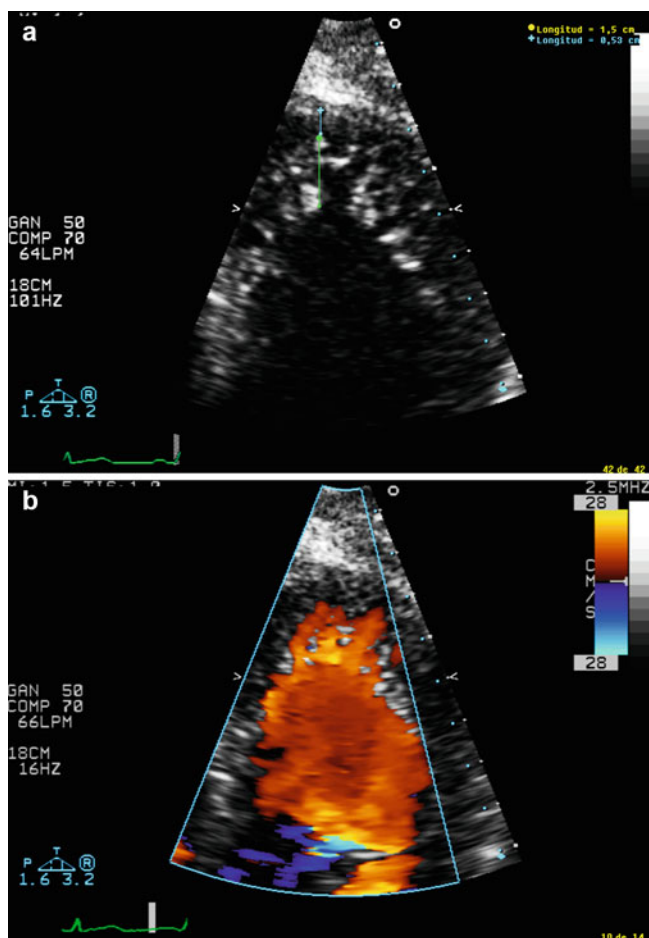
Apical view in a patient affected by not-compacted cardiomyopathy. Color Doppler shows endocardial non-compacted zone filled with blood from the ventricular cavity
